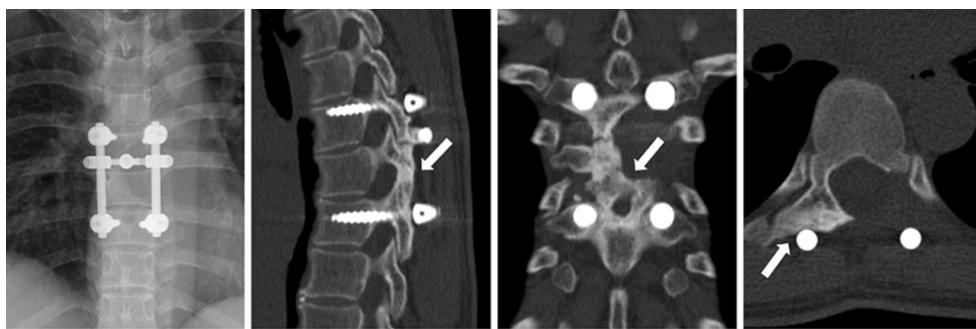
Postoperative radiography and computed tomography images obtained 3 years after spinal surgery. At the 3-year post-surgery follow-up, there was no loosening of the posterior instrumentation. Bone union after frozen recapping laminoplasty was obtained (white arrows)
